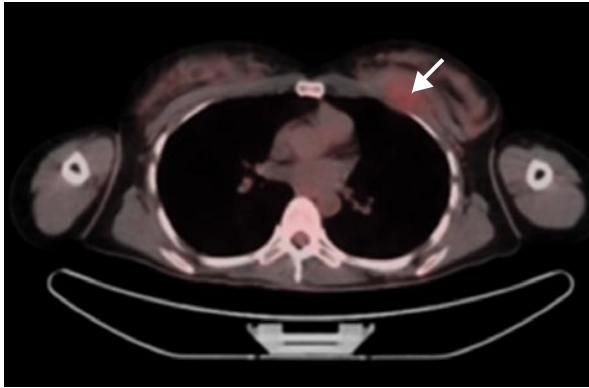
Positron emission tomography/computed tomography scan showing a moderately hypermetabolic (standardized uptake value 2.7) soft-tissue density mass (arrow) involving the chest wall.
